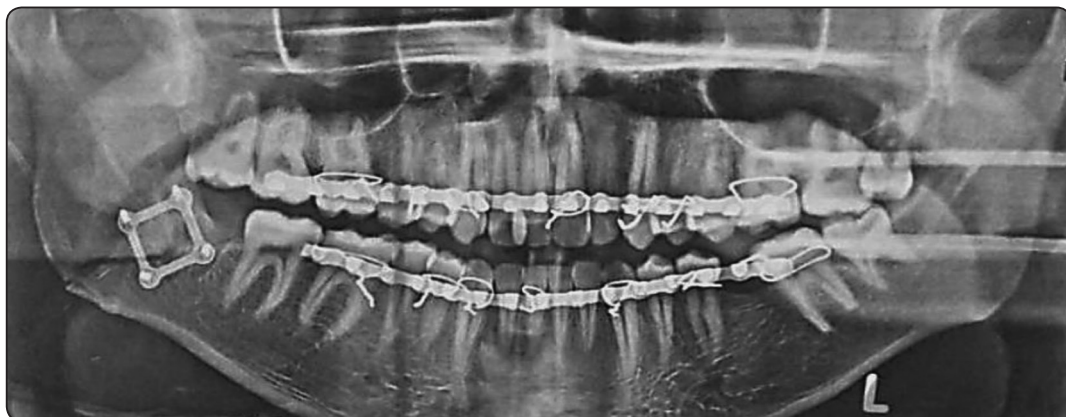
Panoramic radiograph showing fixation of angle fracture with 4 holes 3d-strut plate.
